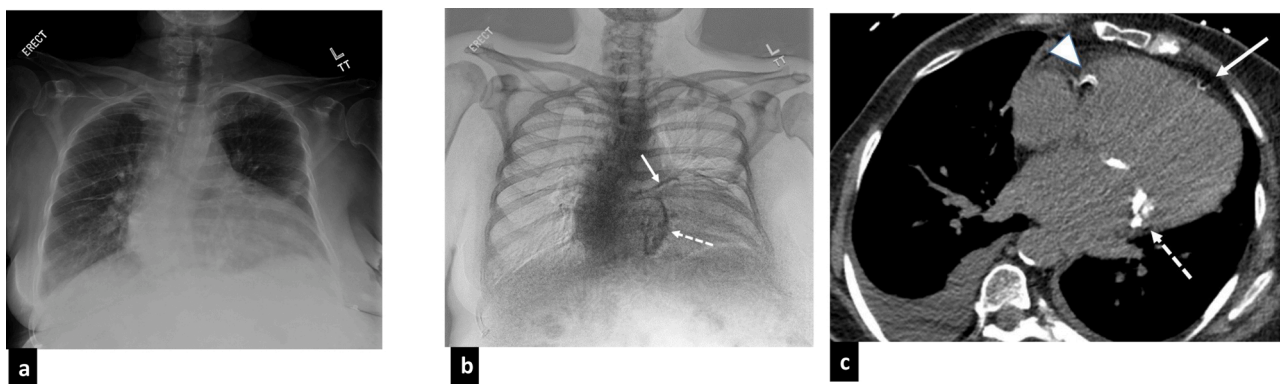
Improved depiction of cardiovascular calcifications in a 70-year-old female with symptoms consistent with congestive heart failure. Conventional X-ray image (a) shows cardiac enlargement with mild vascular congestion and small bilateral pleural effusions in keeping with provided clinical history. Corresponding bone image(b), shows linear calcifications in the expected location of left anterior descending coronary artery (blue arrow) and prominent mitral annular calcification (orange arrow), which were also seen on chest CT (c). Additional right coronary artery calcifications were also seen (white arrow in c), which were likely obscured by scoliotic thoracic spine on radiograph.
